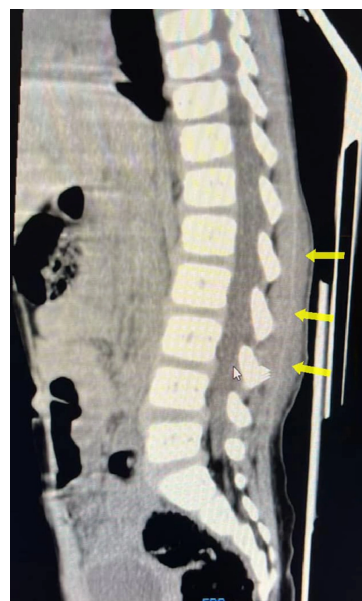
Non-contrast sagittal computed tomography (CT) image of the spine shows subcutaneous tissue edema (arrows) in the lumbar region
